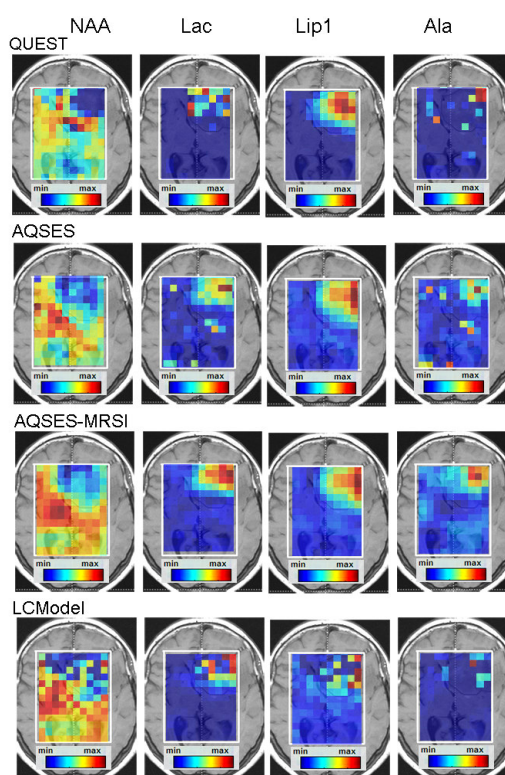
Metabolic maps obtained after applying *QUEST*, *AQSES*, *AQSES-MRSI* and *LCModel*. The color scheme is relative to each metabolite. The patient is diagnosed to have a glioblastoma (upper right corner of the MRI image).
